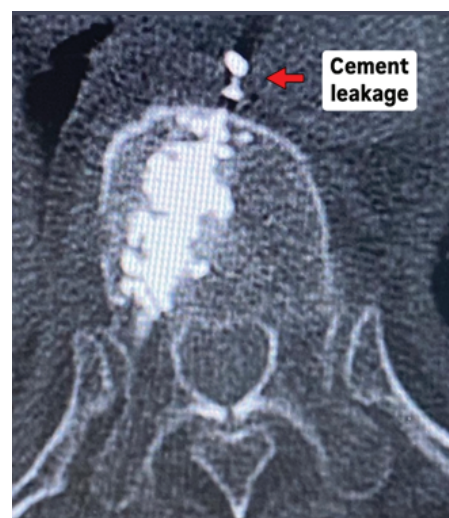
Postoperative CT scan, bone phase in the axial cut at the thoracic level, showing extravasation of bone cement.
